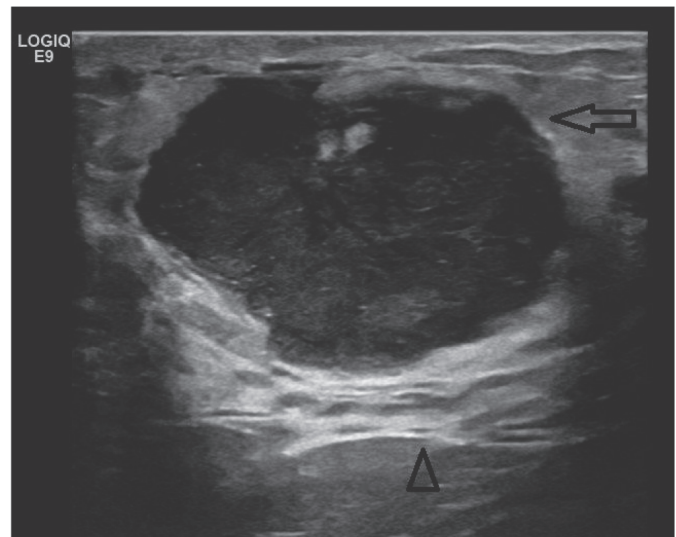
An ultrasound image of the left breast. Arrow indicates the hypoechoic lesion with posterior acoustic enhancement (arrowhead).
